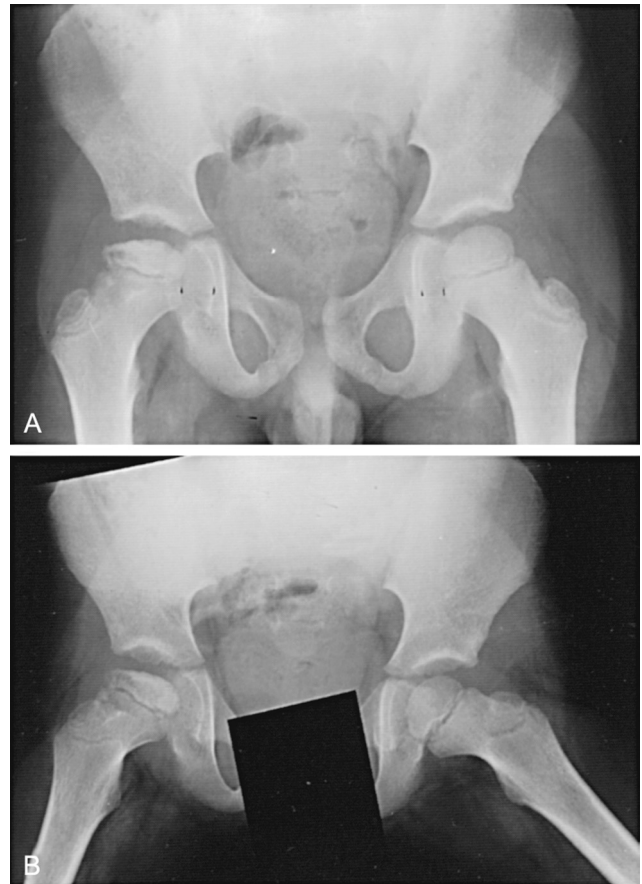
A, An anteroposterior radiograph of the pelvis demonstrating Legg–Calvé–Perthes disease (LCPD) of the right hip. The capital femoral epiphysis (CFE) is collapsing, and there is mild widening of the medial joint space. The left CFE is normal. B, A frog-leg lateral radiograph of the pelvis demonstrating limited hip abduction caused by LCPD.
